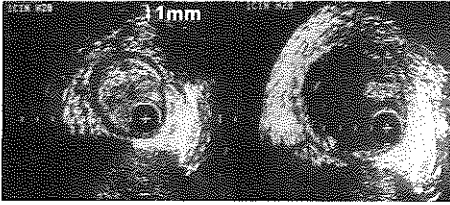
Intravascular ultrasound cross-sections obtained before (left) and after (right) balloon angioplasty of the superficial femoral artery. The lumen area is completely obstructed by a soft lesion and is circumscribed by the hypochoic muscular media. Following dilatation the lumen area is increased. The hypochoic media is thinned and a small remnant of the lesion is still present.
